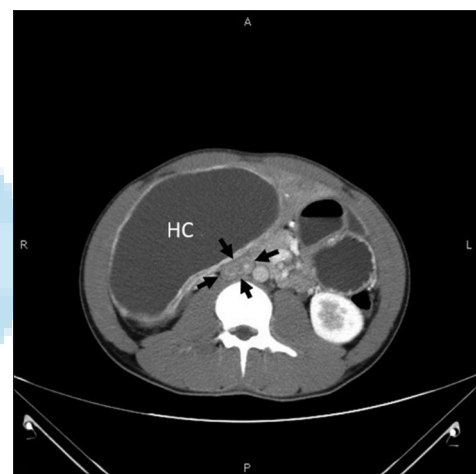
Axial computed tomographic image showing giant hepatic cysts with partial compression of the inferior vena cava (arrows)
